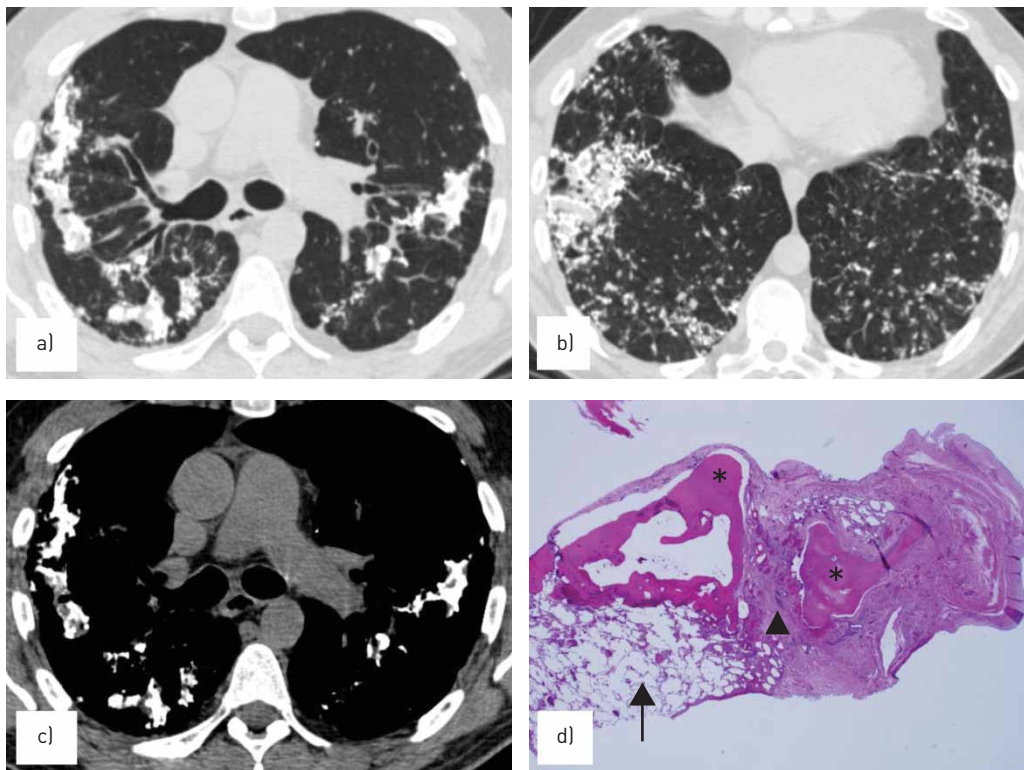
a, b) Computed tomography (CT) images of the chest showing diffuse nodular lesions that appear to be densely calcified. c) CT image with mediastinal window showing the lesions which have bone density. d) Video-assisted thoracoscopy lung biopsy showing spicules of bone (asterisk) with adjacent fibrosis (arrowhead) and normal appearing lung tissue (arrow).
